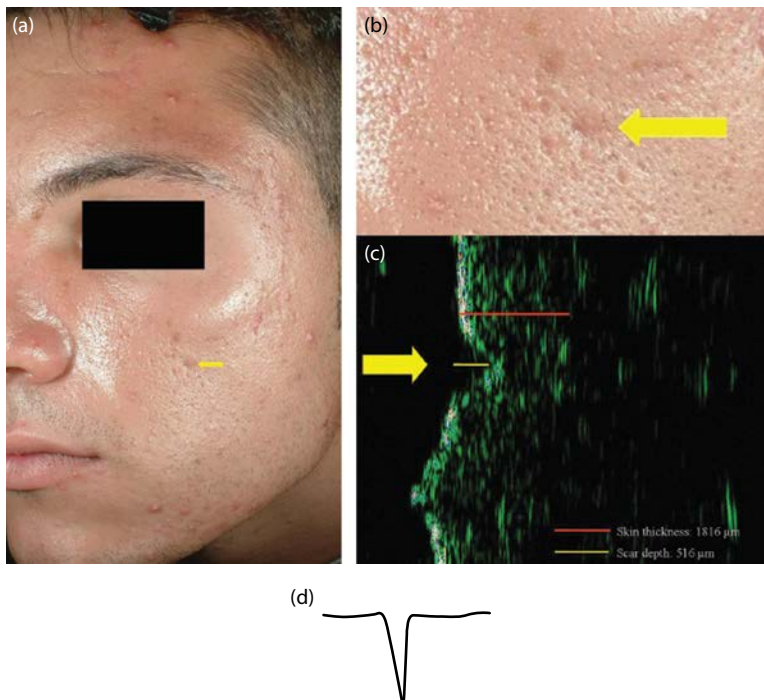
Ice pick scar: (a,b) clinical and (c) ultrasound appearance; (d) cross-sectional profile.
